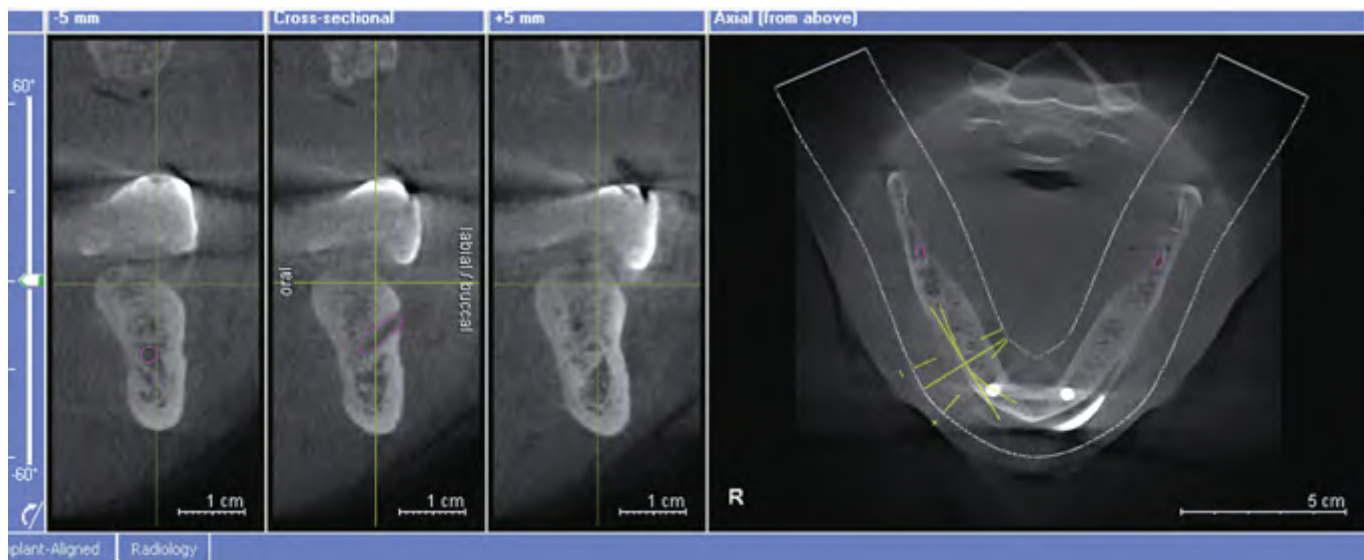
Screen shot of the right posterior mandibular segment's CT scan, with the scanning appliance in place. The location of the right mental nerve was clearly identified on the lateral cross-sectional image (left side of image). The location of the right inferior alveolar nerve was also clearly seen (purple circle). The location of the slice was indicated by the line on the occlusal view of the mandible (right side of image).
